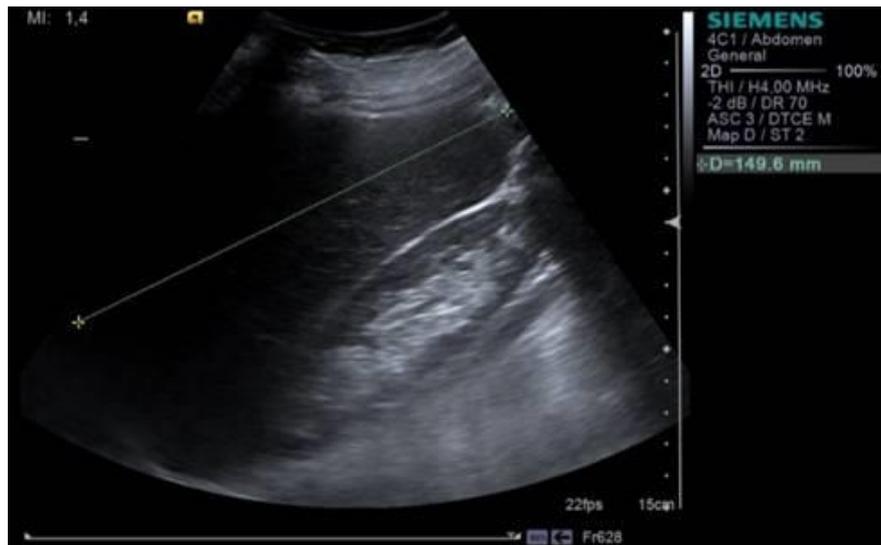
Abdominal ultrasound revealing splenomegaly
